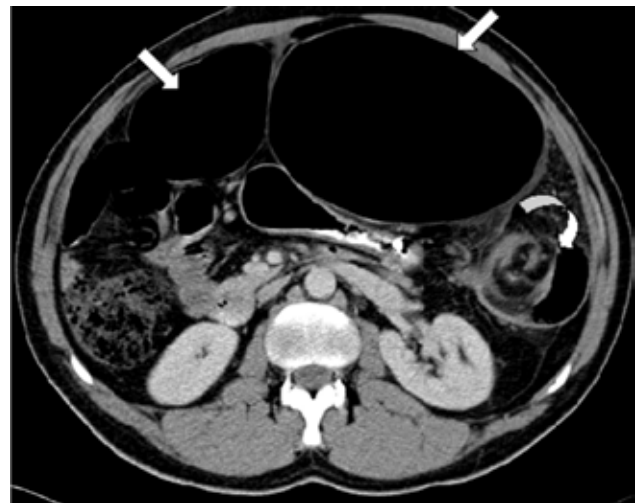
CT scan revealing the 2 dilated loops of the splenic flexure (straight arrows) with the characteristic whirl sign (curved arrow). CT-computerised tomography.
